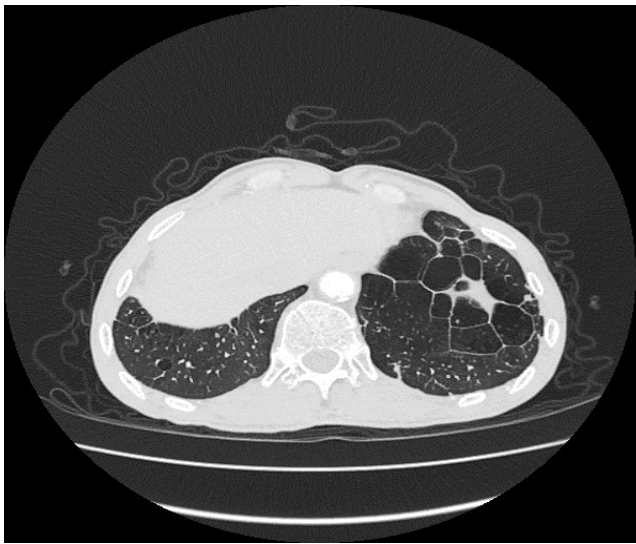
Patient 2 (chest CT scan).
